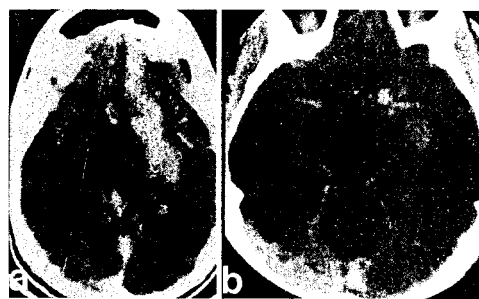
a*, Preoperative CT scan demonstrating a left frontotemporal intracerebral hemorrhage. *b*, Infusion CT scan revealing an aneurysm of the carotid bifurcation (arrow) responsible for the hemorrhage. The M1 and A1 segments are visible (arrowheads).
